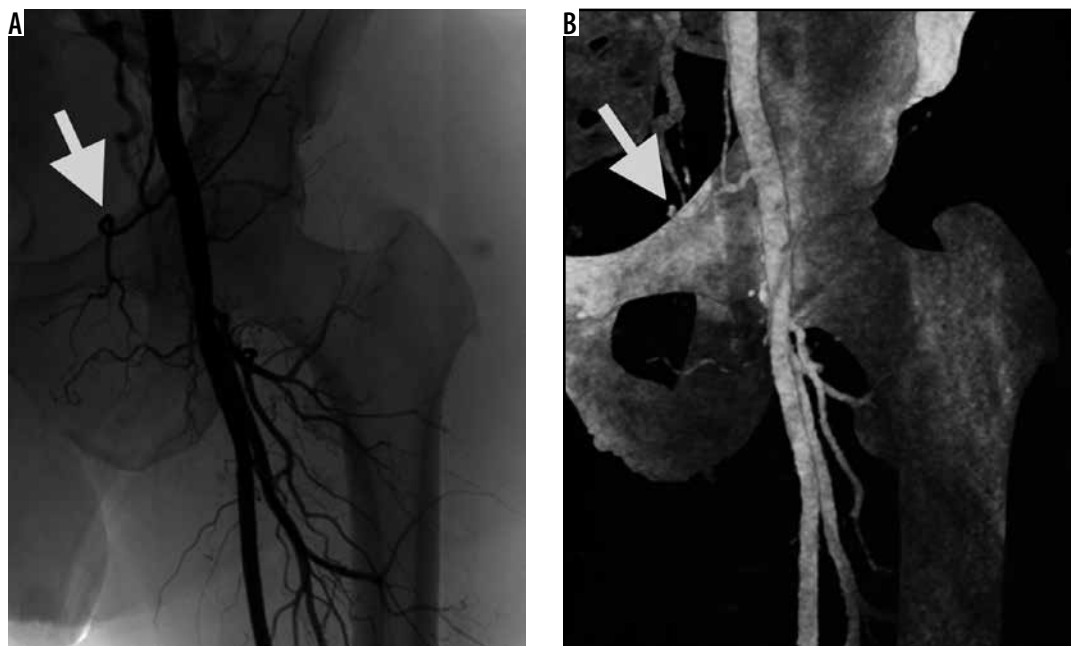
Angiographic run-off (A) and shaded surface rendering of a vascular CT study (B) showing the presence of the arterial corona mortis variant on the left side (arrowheads), with a large-calibre artery arising from the left external iliac artery and coursing above the pubic bone
